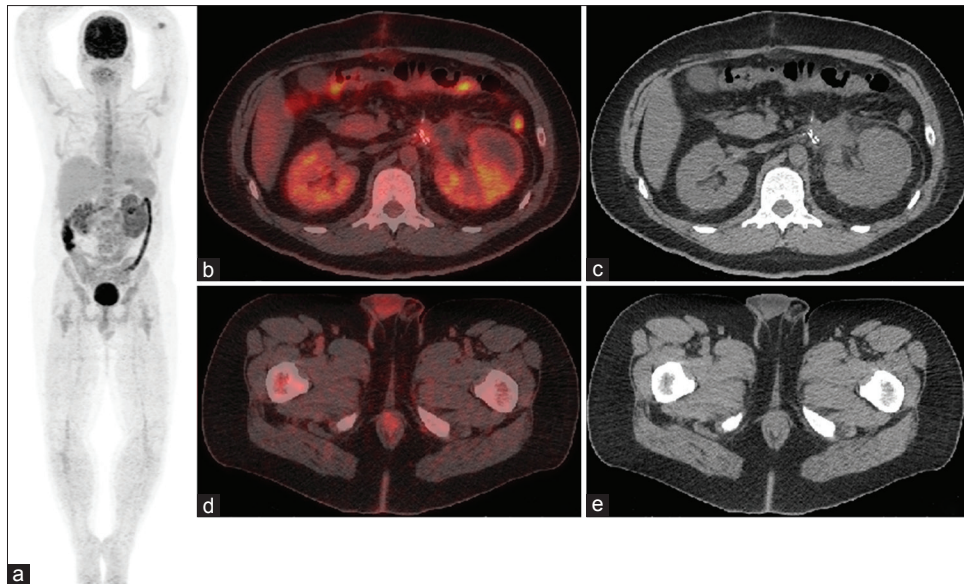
(a) 18 fluoro-2-deoxyglucose-positron emission tomography/computed tomography (FDG-PET/CT) maximum intensity projection image weeks after surgery. (b) Axial hybrid PET/CT of the region that previously showed high FDG activity in the retroperitoneal mass. (c) Corresponding computed tomography attenuation correction (CTAC) image. (d) Axial hybrid PET/CT showing decreased FDG activity in the right testis after surgery. (e) Corresponding CTAC image
